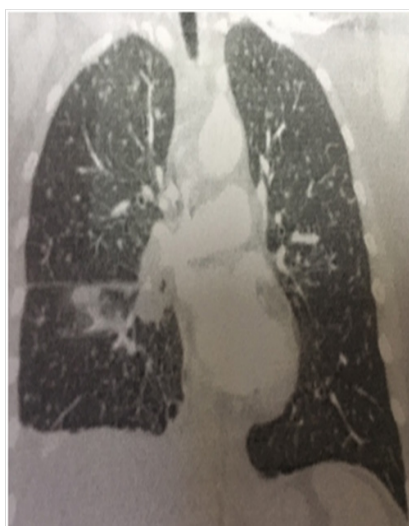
Coronal computed tomography revealing right lower anterior segment infiltration, right pleural effusion, and diffuse miliary nodules.
